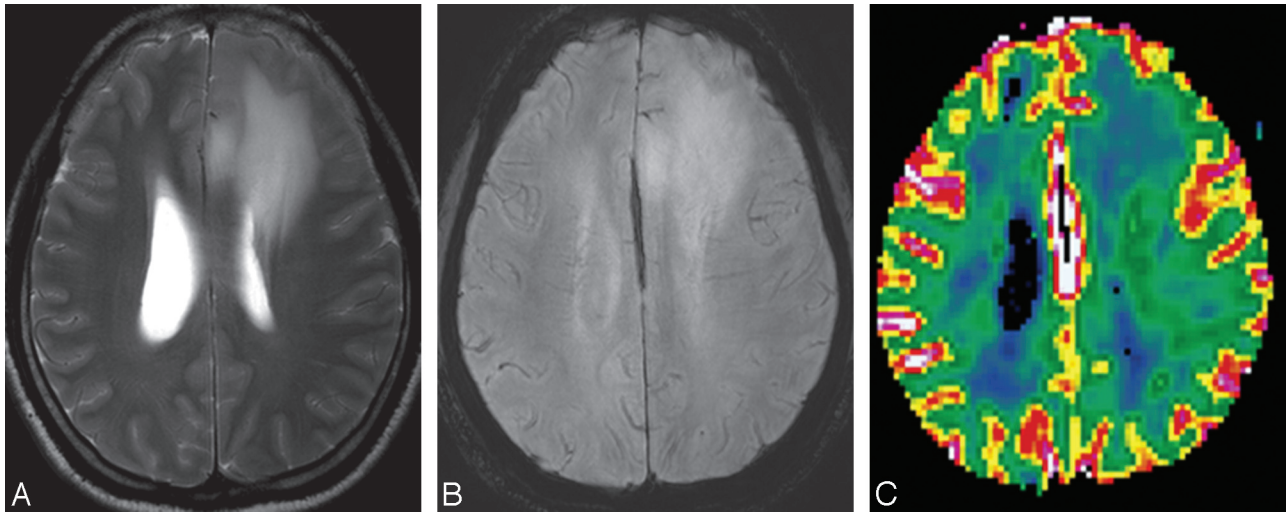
MR images of a 39-year-old woman with left frontal low-grade astrocytoma (WHO grade II). *A*, The axial T2-weighted image shows an ill-defined mass with high signal intensity in the left frontal lobe. *B*, HR-SWI demonstrates no evidence of the ITSS. *C*, Corresponding rCBV map shows relatively low rCBVmax values of 1.31.
